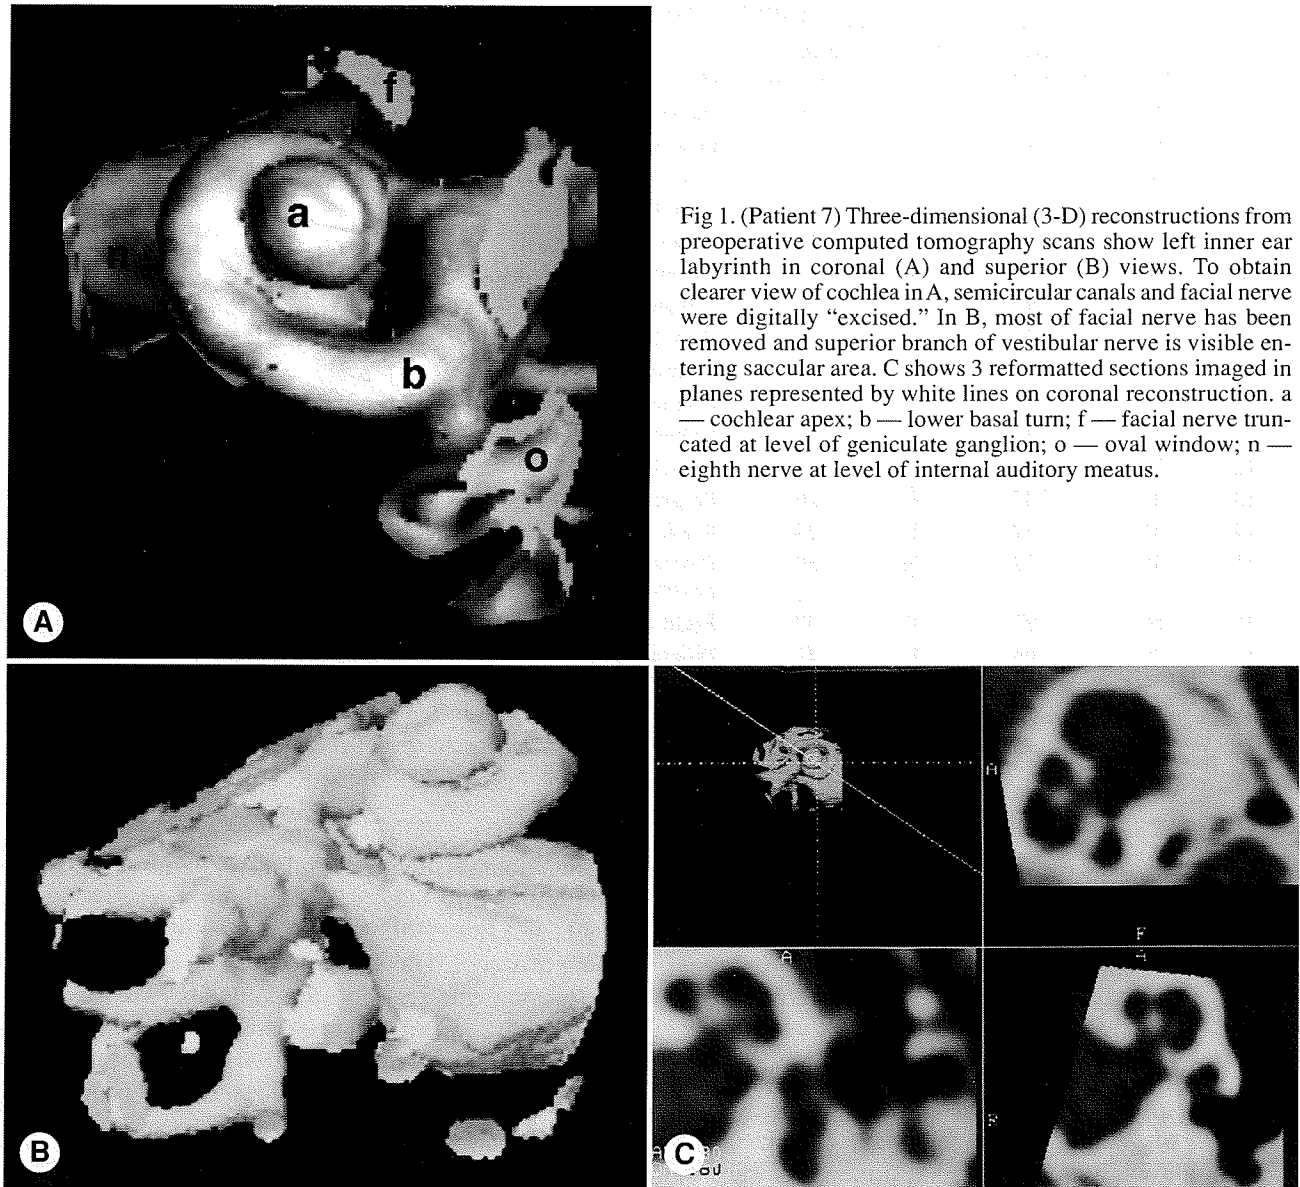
(Patient 7) Three-dimensional (3-D) reconstructions from preoperative computed tomography scans show left inner ear labyrinth in coronal (A) and superior (B) views. To obtain clearer view of cochlea in A, semicircular canals and facial nerve were digitally "excised." In B, most of facial nerve has been removed and superior branch of vestibular nerve is visible entering saccular area. C shows 3 reformatted sections imaged in planes represented by white lines on coronal reconstruction. a — cochlear apex; b — lower basal turn; f — facial nerve truncated at level of geniculate ganglion; o — oval window; n — eighth nerve at level of internal auditory meatus.
